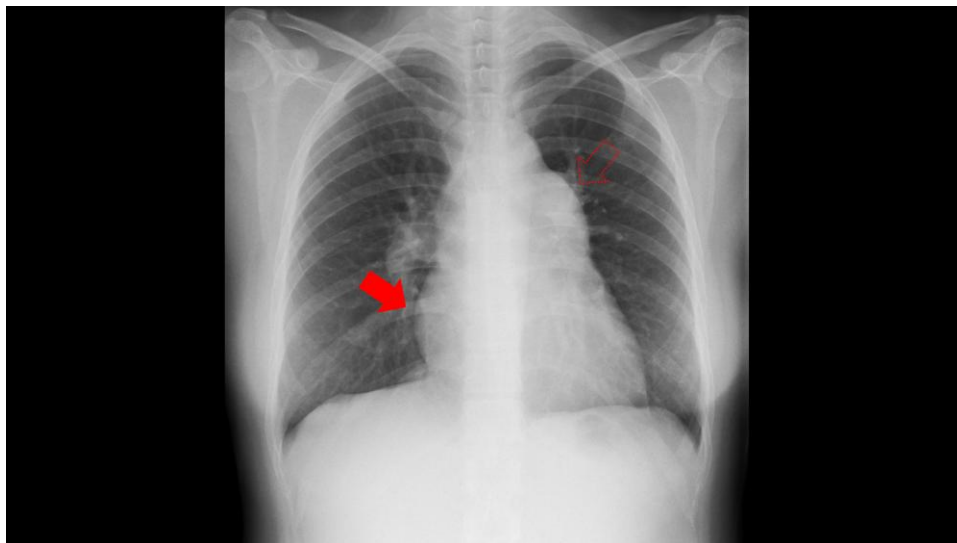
An initial chest X-ray. A chest X-ray indicated an enlarged left pulmonary artery (dotted arrow) and a protrusion of the right atrium (solid arrow), suggesting pulmonary hypertension.
